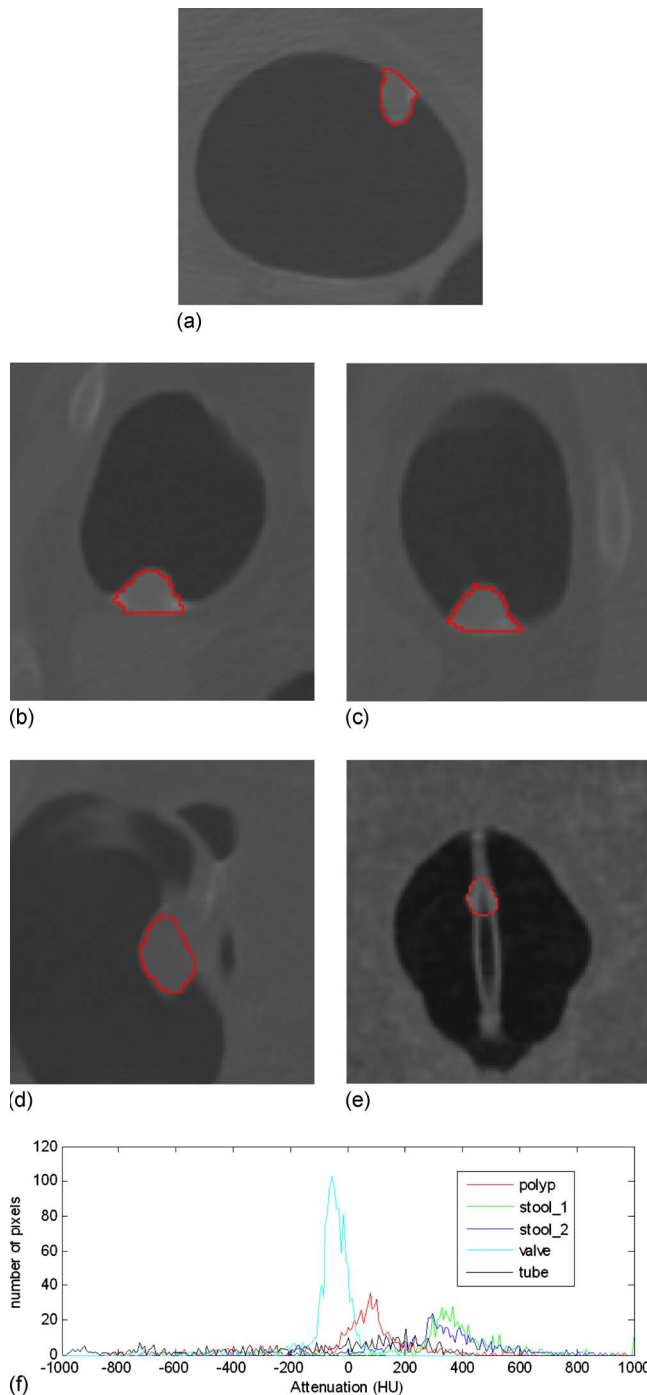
The histograms (bottom figure (f)) of CT density distribution of five VOIs, which are indicated by the closed curves in the above five pictures. From (a) to (e), the objects are a polyp, two stools (i.e., the stool_1 and stool_2 in (f)), an ileocecal valve, and a rectal tube.
